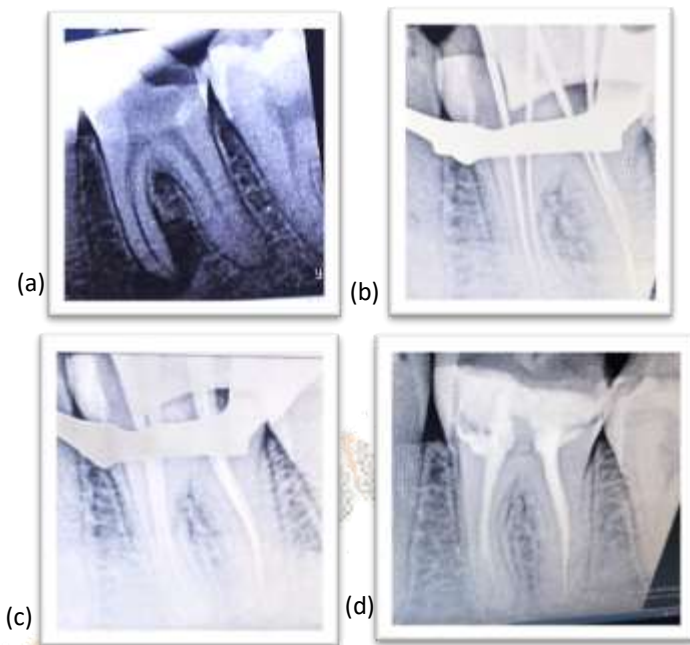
(a) pre-operative radiograph
